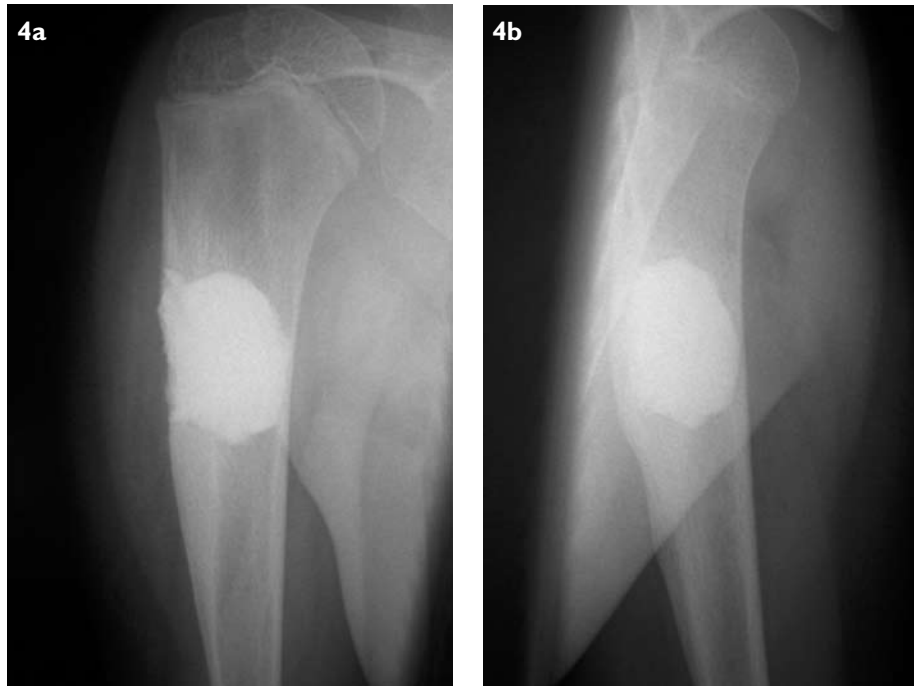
Follow-up (a) AP and (b) lateral radiographs of the right proximal humerus show calcium phosphate cement filling the previous tumour site and no evidence of recurrence.
